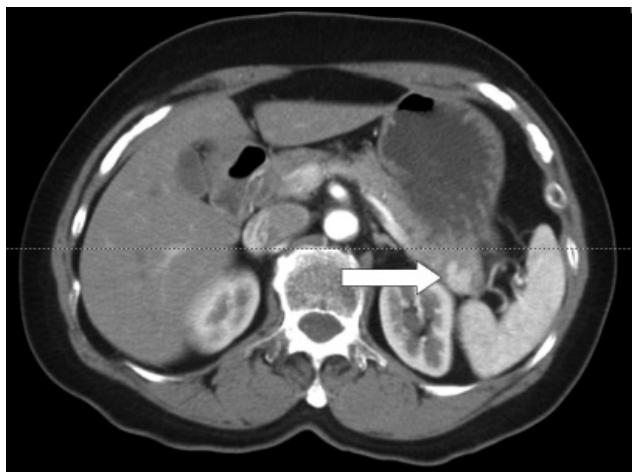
CT scan of abdomen revealed a 1.2 cm arterially enhancing pancreatic mass (white arrow).
